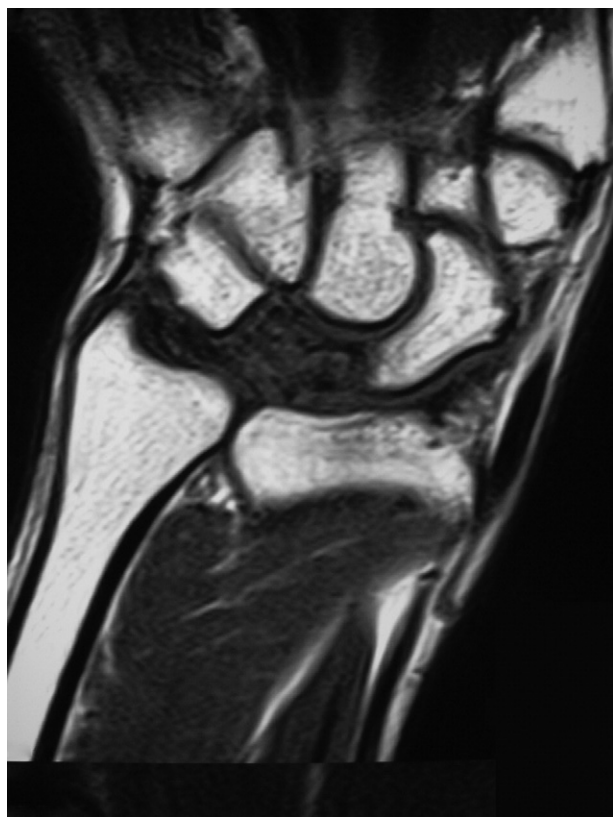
Preoperative T1-weighted MRI demonstrates decreased signal intensity of the lunate.
